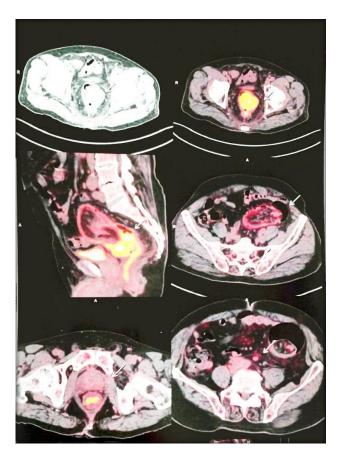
PET-CECT demonstrating the FDG avid lesion at the apex of the intussusception at the recto-sigmoid.
